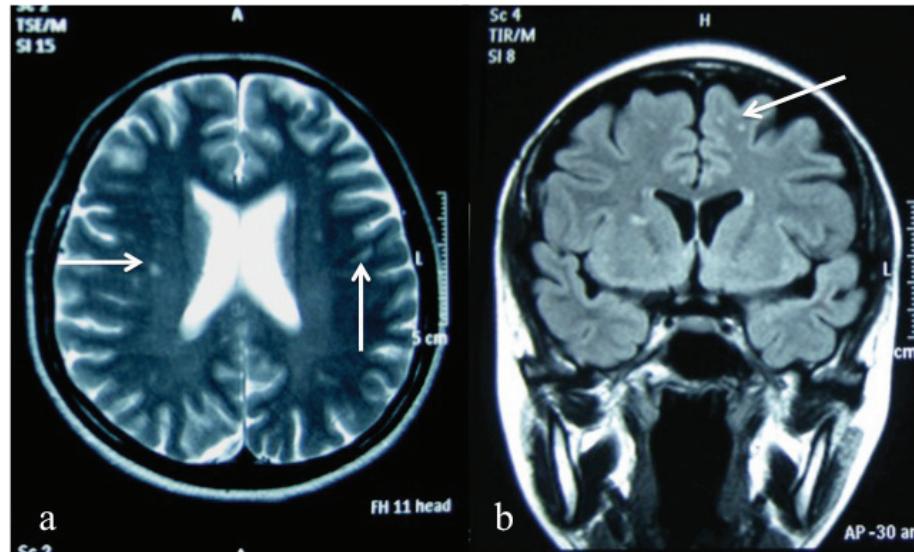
Magnetic resonance imaging (MRI) in 2007 when the patient had dizzy spells, before the onset of definite neurological illness. a) Axial T2W and b) coronal FLAIR of the brain showing non-enhancing multiple hyperintensities in the subcortical and deep white matter of the parietal lobes (white arrows) probably from asymptomatic Nipah virus infection in 1999.
